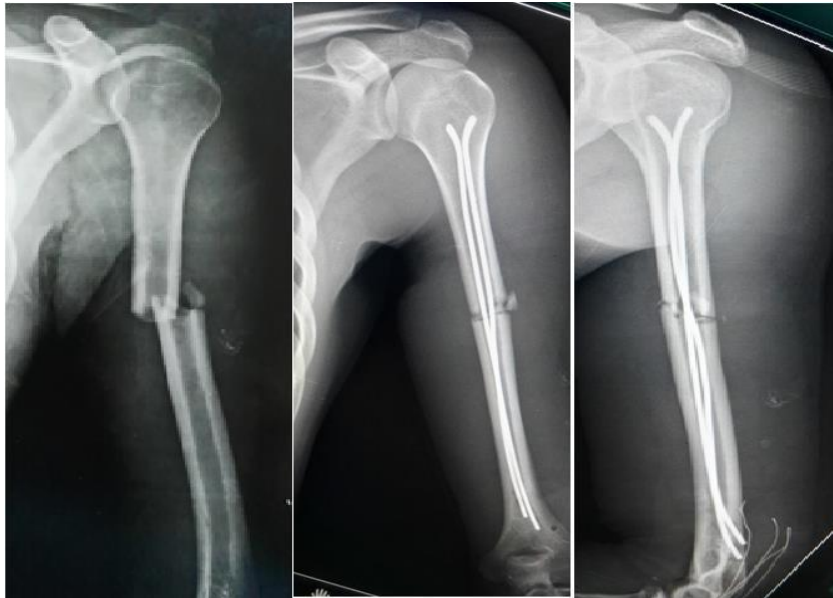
Pre and postoperative x-rays
